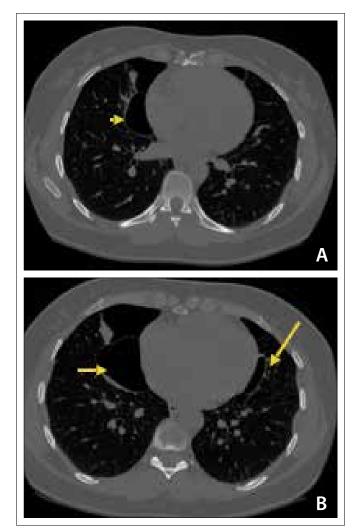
(A) Computed tomography (CT) scan showing cysts in a paracardiac distribution (yellow arrowhead); (B) CT scan showing cystic changes (yellow arrows).
